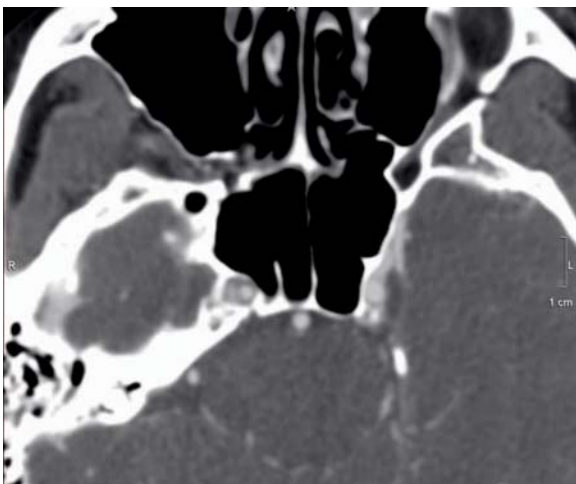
Carotid traumatic dissection. CTA is used extensively to evaluate patients with significant trauma. Here, the right distal petrous internal carotid artery (ICA) is dissected in a patient post motor-vehicle collision. The compromised lumen is seen medial to the dissection laterally
